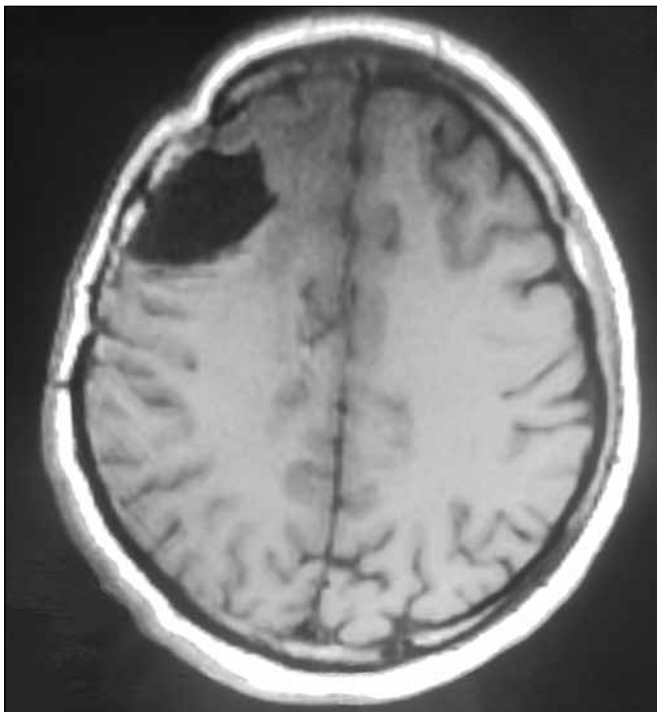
Follow-up T1-weighted brain MRI obtained 6 months after surgery revealed complete resolution of the lesion with a persisting pseudocyst defect.
